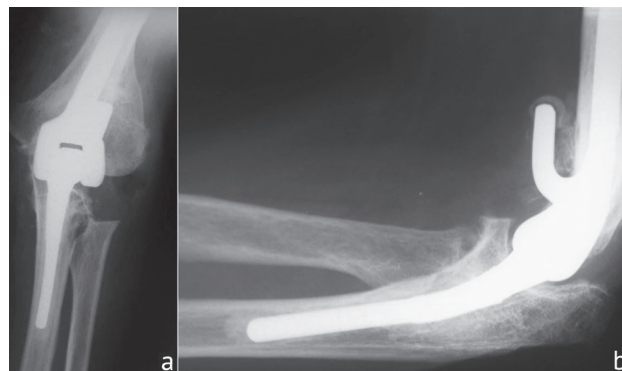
Patient N radiographs of the elbow joint one year after TEA: a – AP view; b – lateral view
